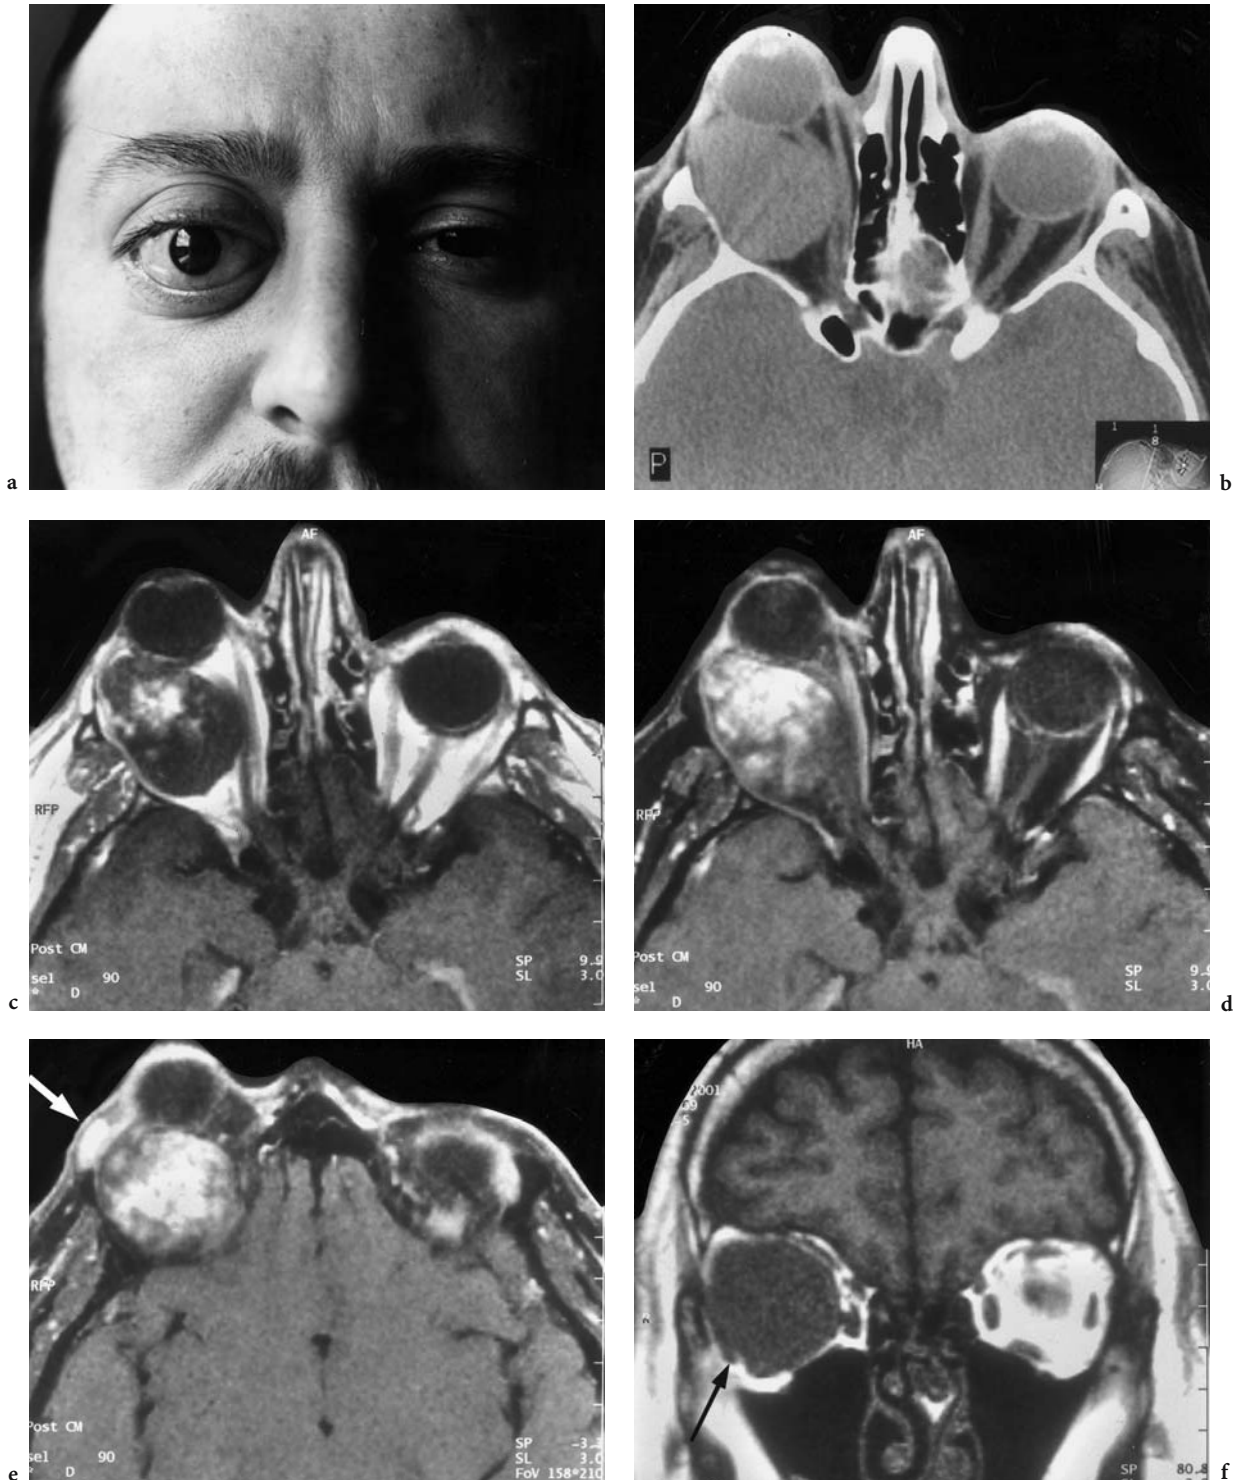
A 32-year-old man with extreme proptosis of the right eye for more than 15 years, who presented with the complaint of progressive visual deficit. Diagnosis: cavernous hemangioma. a Portrait of the patient with extreme protrusion of the right eye. CT: b Axial view with exophthalmos measurement of 33 mm. Sharply defined, encapsulated, intraconal tumor lateral of the optic nerve with medial dislocation and slight compression of the medial rectus muscle. Note the medial dislocation of the optic nerve at the entrance to the optic canal. The resulting hypomochlion may be accountable for the visual impairment. MRI: c Corresponding axial T1-weighted native view with apparent impression of the globe. d Corresponding T1-weighted, contrast-enhanced (FS) view. d Axial, T1-weighted, contrast-enhanced (FS) view of the upper orbit, showing the extraorbital dislocation of the lacrimal gland (*white arrow*). f Coronal T1-weighted native view. The entire orbit is occupied by the cavernoma. Note the close vicinity of the optic nerve to the medial rectus muscle and flattening of the other external muscle with inferior dislocation of the lateral muscle (*arrow*)
